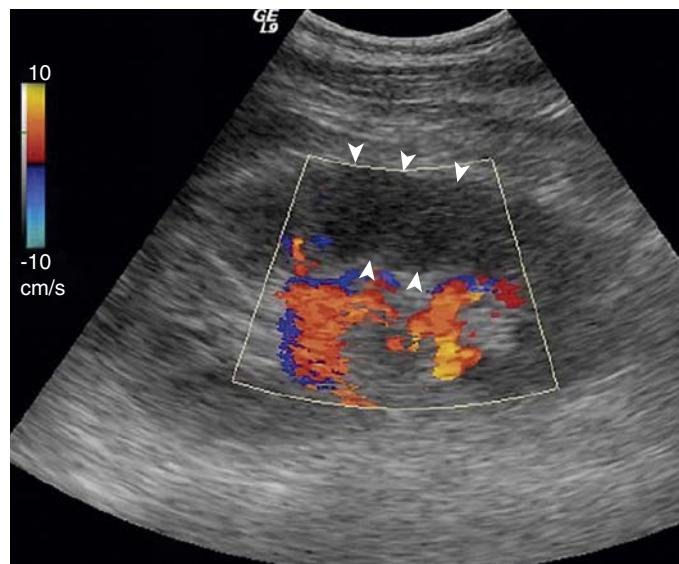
Renal Infarction Demonstrated by Duplex Ultrasound. Renal infarction caused by arterial embolism appears as a wedge-shaped hypoechoic area with absence of blood flow signal (arrowheads). (From Cai S, Ouyang YS, Li JC, et al. Evaluation of acute renal artery thrombosis or embolism with color Doppler sonography. *Clin Imaging*. 2008;32(5):367–371.)
